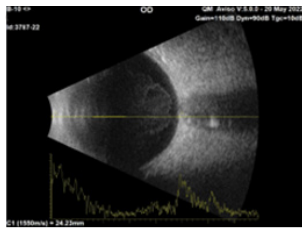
Ultrasonography of the right eye showed vitreous opacification. disc had a cup-disc ratio of 0.3, and the neuroretinal rim was normal, according to the ISNT rule. Other funduscopy examinations of the left eye were within normal limits, with no glaucomatous optic neuropathy.
